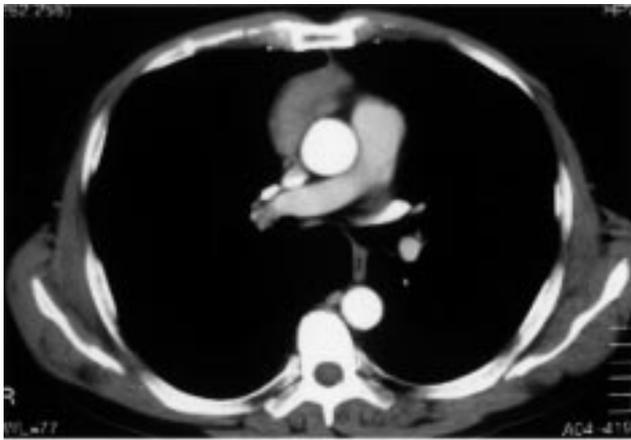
A chest computed tomography scan revealed an anterior mediastinal tumor.
